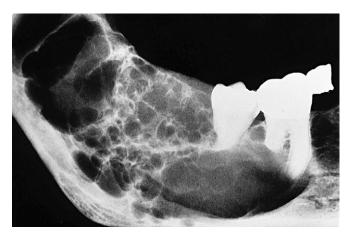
Radiograph, showing the classic appearance of ameloblastoma involving the mandible. The lesion is expansile and multilocular, with numerous well-defined internal septations. Note the erosion of adjacent tooth roots.
